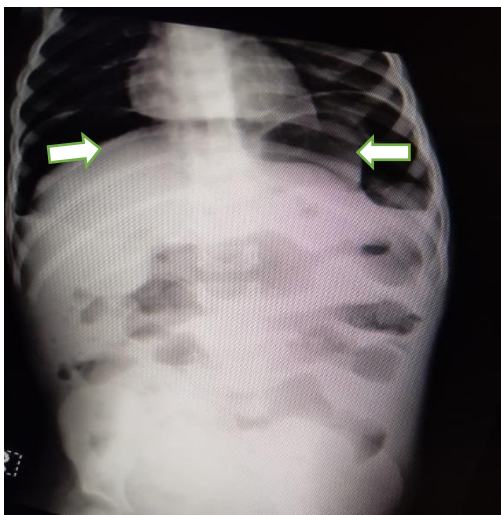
Abdominal radiograph (erect view) showing bilateral sub-diaphragmatic free air (Arrow) - Chilaiditi sign.
